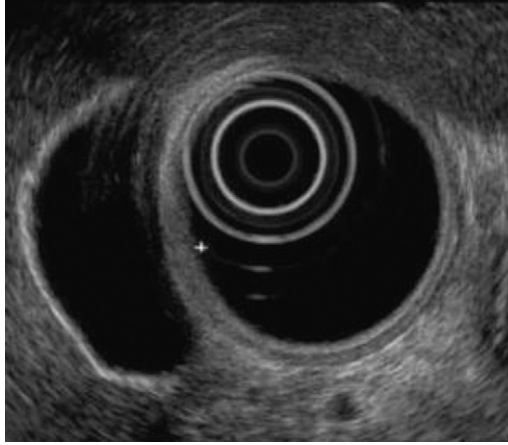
Endosonographic image of a normal gallbladder from the duodenal bulb. The gallbladder appears as an anechoic (fluid-filled) structure with a thin layered wall.
